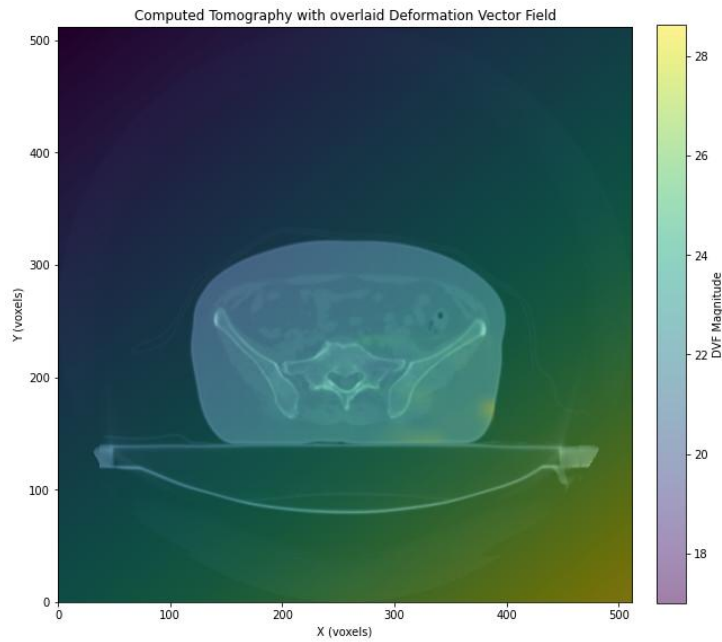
Axial slice of the planning CT overlaid with the magnitude of the DVF.
